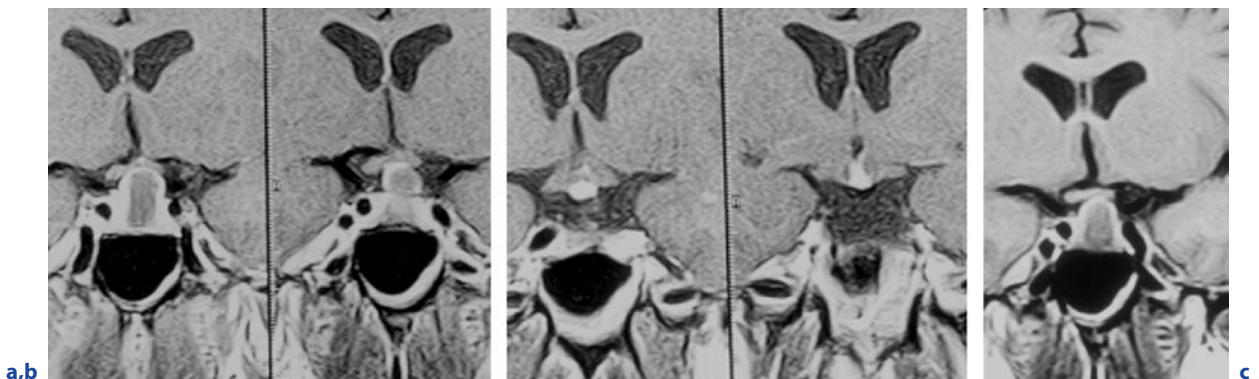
Neurosarcoidosis with involvement of the pituitary stalk before, under, and after breaking off steroid treatment. a–c Coronal T1-weighted images after contrast administration. Enlargement of the pituitary stalk with ring enhancement at
